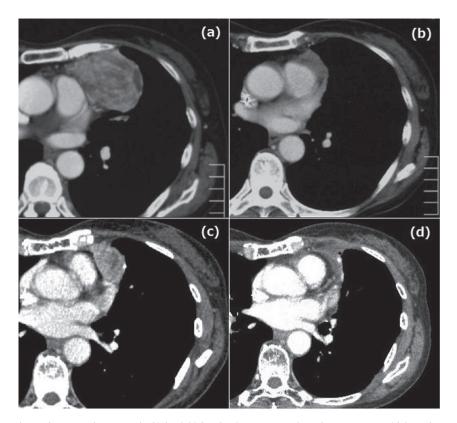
(a) Contrast-enhanced computed tomography (CT) at initial evaluation. An approximately 50 mm mass with irregular contrast enhancement is apparent in the anterior mediastinum. The border is relatively distinct. (b) After preoperative chemotherapy, the tumor has decreased in size. (c) CT at the time of recurrence. An approximate 25 mm tumor with contrast enhancement is seen at the resection site. (d) Post-radiotherapy CT. The tumor has disappeared. No serious radiation pneumonitis developed, and the patient has been stable for six years without tumor recurrence.
